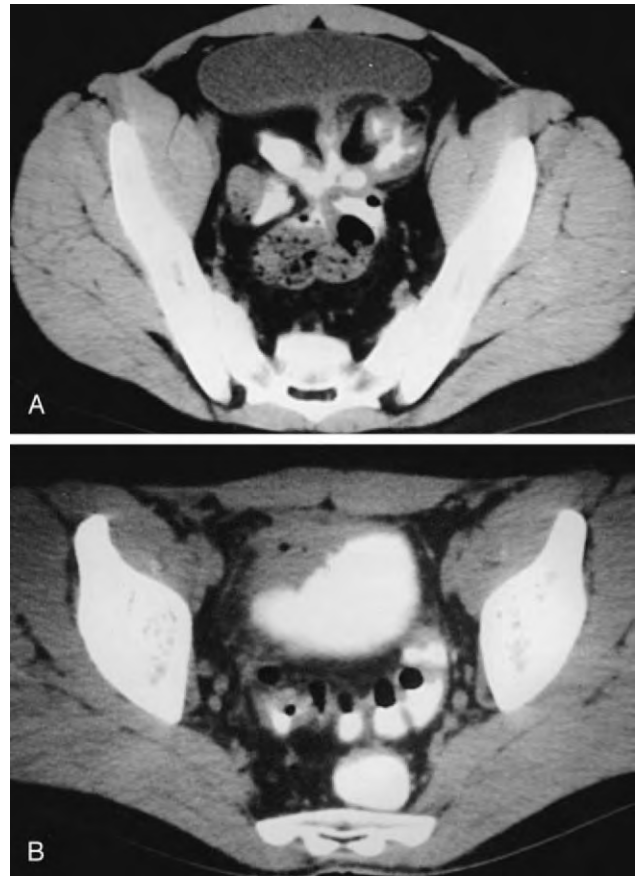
Computed tomographic scans in patients with enterovesical fistulas A, Complex enteroenteric and enterovesical fistula. B, A loop of small intestine is adherent and causing significant inflammation on the wall of the bladder with subsequent fistula formation.
